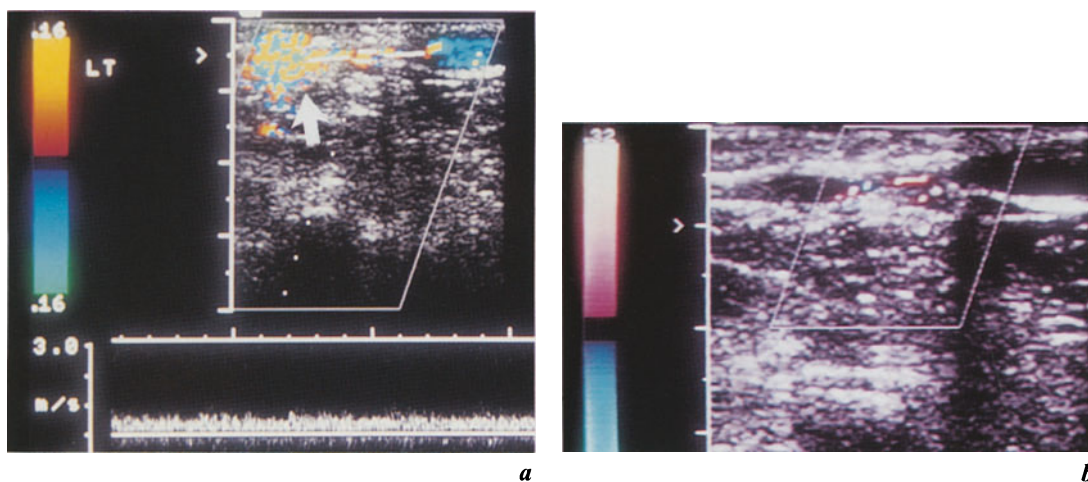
Marked perivascular color artifacts due to a venous stenosis: the artifacts occur only in a circumscribed segment of the vessel (arrow) where they mask the underlying stenosis. Distally (right side of the picture) there are no such artifacts and the vessel lumen is displayed normally (blue). Note the absence of systolic velocity peaks in the Doppler waveform tracing
